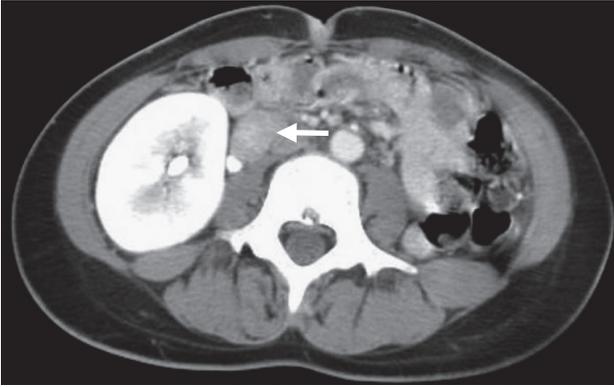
Computed tomography of the abdomen demonstrated a soft tissue mass located behind the right kidney that was 23 mm in diameter.
